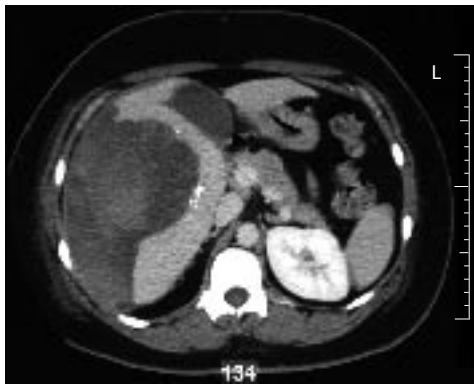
Contrast-enhanced computed tomography (CT) scan of the abdomen 6 d after selective arterial embolization, showing liver hemorrhage with a circumscribed mass as its conceivable origin.
